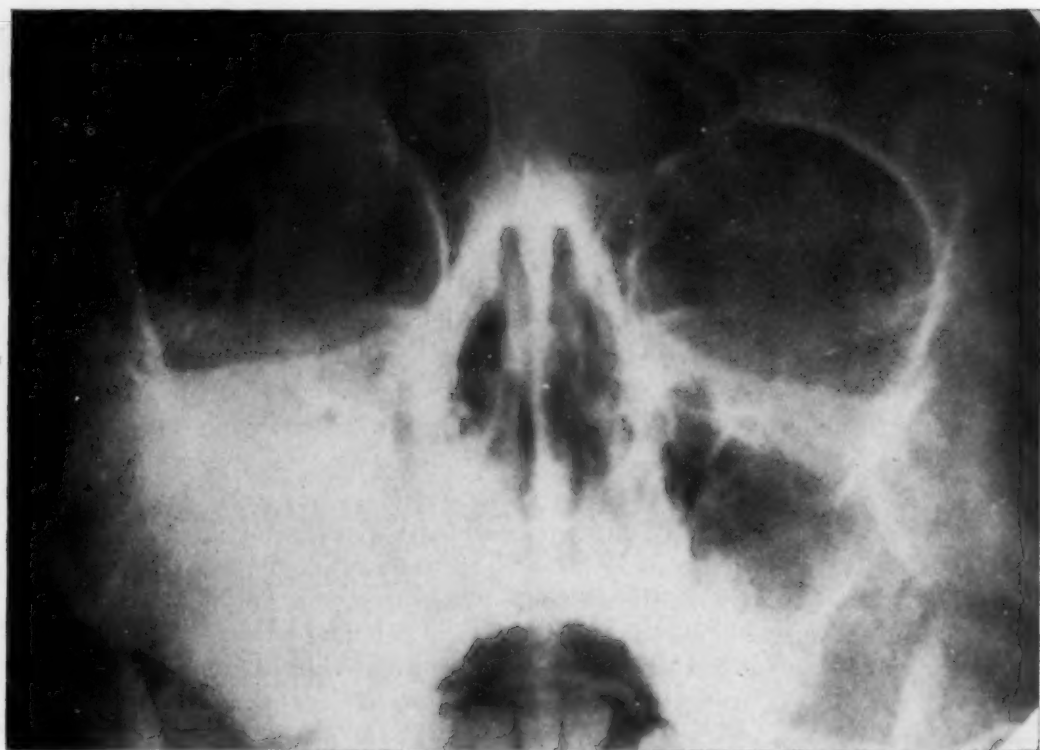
X-ray of fibro-osteoma of maxilla and malar bone involving maxillary sinus.
